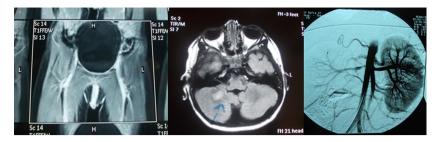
MRI of external genitalia and brain, MRA of renal arteries.
